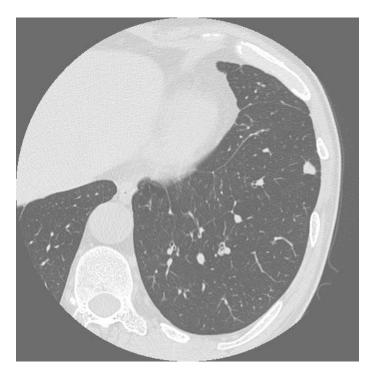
Thin-section CT image acquired under scanning conditions of 150 mAs, and 0.5 mm X 16 rows, and reconstructed at 1-mm intervals and a 1-mm slice thickness. A solid nodule is located in segment 8 of the left lower lobe. The nodule is polygonal in shape, and a linear shadow is visible between the nodule and the pleura. This solid nodule is thought to be an intrapulmonary lymph node.
